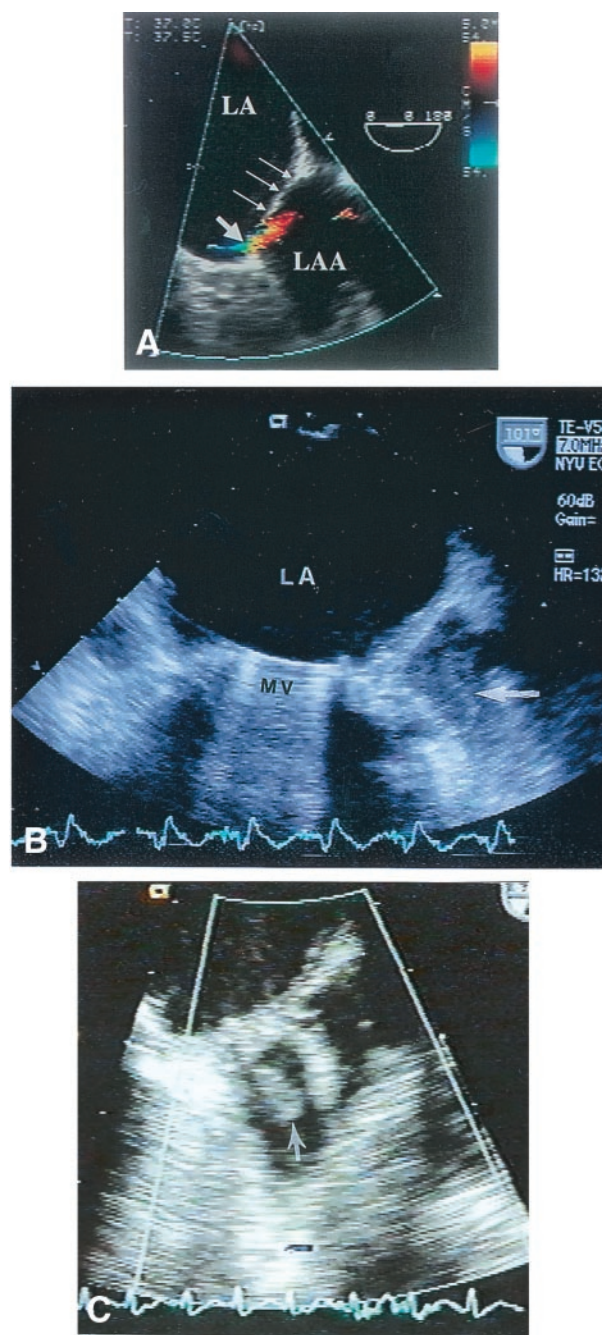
(A) Transesophageal echocardiogram, transverse plane, of an incompletely ligated LAA. Color flow traverses the separation between the LAA and the left atrial body (bold arrow). The ligation suture line is shown with thin arrows. (B) Vertical plane transesophageal echocardiogram of a patient with a mitral mechanical prosthesis and an incompletely ligated LAA. Note the presence of spontaneous echo contrast (arrow) in the LAA compared with the relative absence of this finding in the left atrial body. (C) Vertical plane transesophageal echocardiogram of a patient with a mitral bioprosthesis and an incompletely ligated LAA. Thrombus is seen within the appendage (arrow). LA = left atrium; LAA = left atrial appendage; MV = mitral valve.
